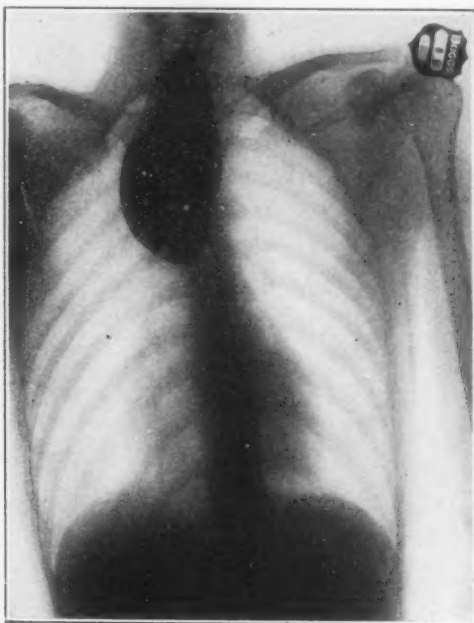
Radiograph (by Dr. Russell H. Boggs) of a woman of 38 years. The shadow, which so much resembles a diverticulum, was esophagoscopically proved to be a dilatation above a luetic stricture. The stricture is behind and above the bottom of the lower border of the shadow of the dilatation. Endoscopic dilatation resulted in a cure.
